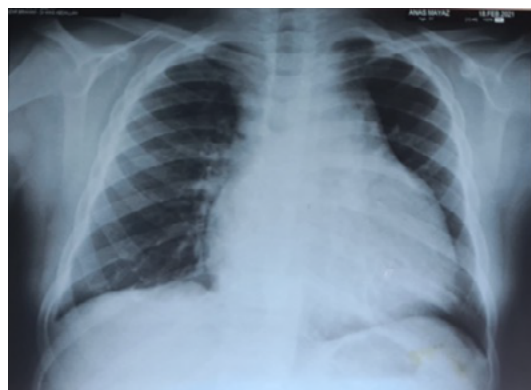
chest X-ray showing importante cardiomegaly
